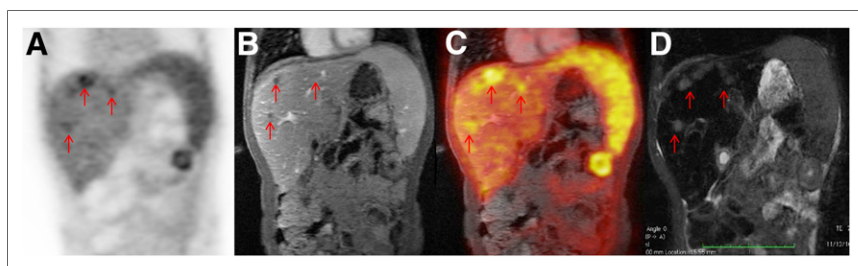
Discordance between ^{18}F -FDG avidity and gadolinium chelate enhancement in 10-y-old boy after treatment for desmoplastic small round cell tumor metastasis. (A) ^{18}F -FDG PET image. (B) Enhanced T1-weighted MR image. (C) Enhanced T1-weighted ^{18}F -FDG PET/MR image. (D) T2-weighted MR image. Hepatic metastases are ^{18}F -FDG-avid, but in this case there are multiple hepatic metastases that apparently do not enhance.
